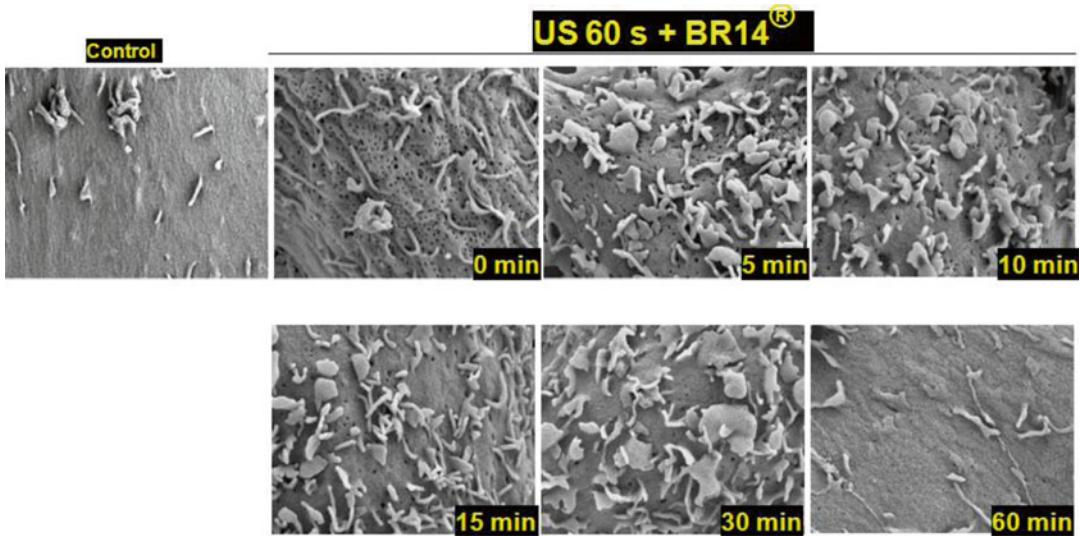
SEM Observations of U-87 MG cells insonified with ultrasound in the presence of BR14 microbubbles. The cells were fixed immediately, and then at different time points after sonoporation
